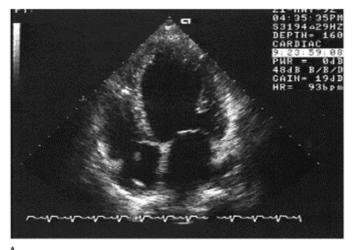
Functional infarct size. Example of a patient in cardiogenic shock from extensive anterior myocardial infarction. Note that only the basal parts of the anterior and lateral wall are moving in systole (marked with arrows). Panels A (diastole) and B (systole) show apical four-chamber view; C (diastole) and D
